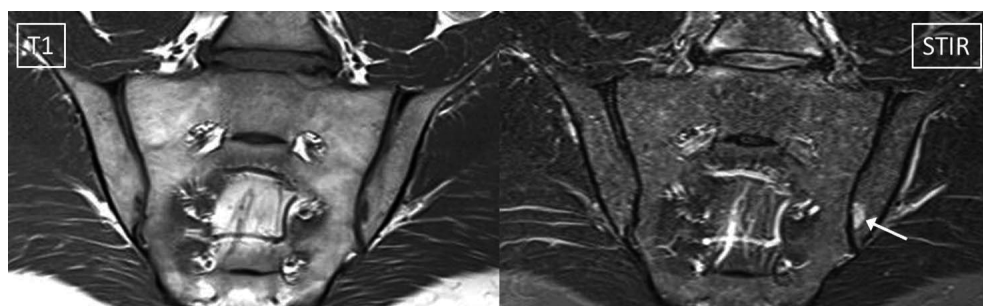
MRI sacroiliac (SI) joints—mechanical back pain. MRI of SI joints in a 31-year-old male with mechanical low back pain of more than 3 months duration. C-reactive protein was normal. On pelvic radiography, the SI joints were normal. The short tau inversion recovery (STIR) sequence shows abnormal increased signal (arrow) in the subchondral bone of the left ilium with a non-specific appearance. Although a BMO lesion is clearly present, it is small and on the T1-weighted sequence an even smaller focus of very low signal is seen in the same location paralleling the articular surface. There was no evidence of structural damage in the SI joints. These coronal images also show evidence of disc degeneration at L5/S1 with loss of height and signal intensity of the nucleus pulposus, bulging annulus and Modic type 1 reactive inflammation (bright on STIR) at the perimeter of the disc. The patient was followed up and the final diagnosis for the cause of the mechanical low back pain was disc degeneration. The cause of the left SI lesion is unproven but it most likely represents a small fatigue stress reaction in association with mild osteoarthritis of the SI joint. These MRI observations are frequently seen in weight-bearing joints as they degenerate.
